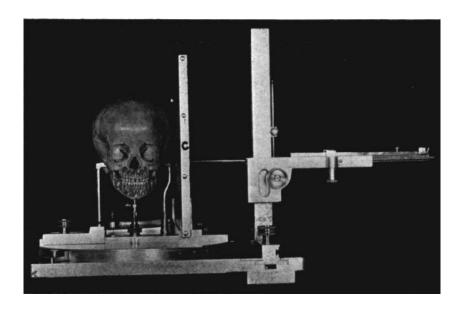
Skull in the craniostat with the cassette in place for the lateral roentgenogram.
